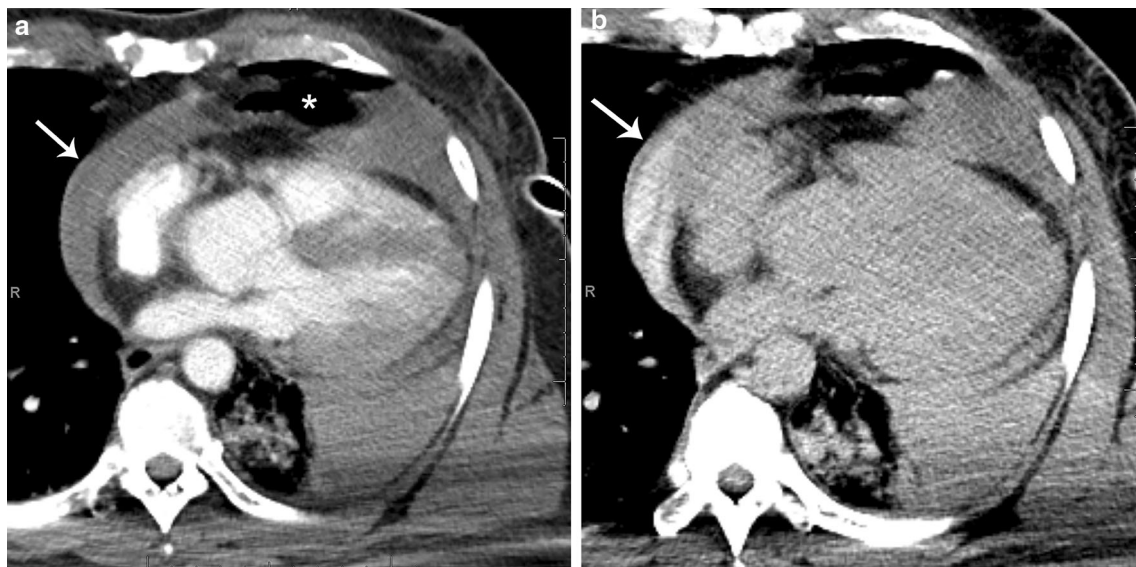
a CT following blunt thoracic trauma demonstrates a large pericardial effusion (arrow) and twisting of the cardiac axis towards the left lateral chest wall. The AP diameter of the heart is narrowed and the heart is shifted to the left. Anterior to the heart is components of pneumothorax and pneumomediastinum (asterisk). Pulmonary contusion and hemothorax are seen posterior to the left ventricle. b The heart was observed on delay images and showed contrast
